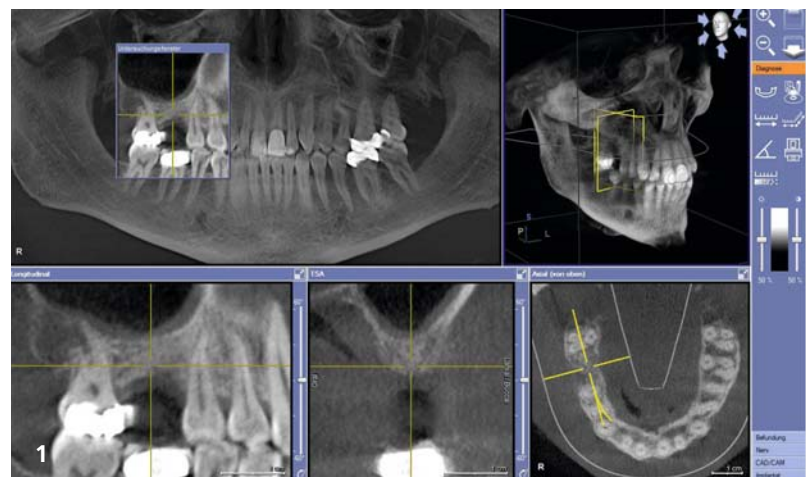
CBCT for preoperative determination of the qualitative and quantitative bone supply.
